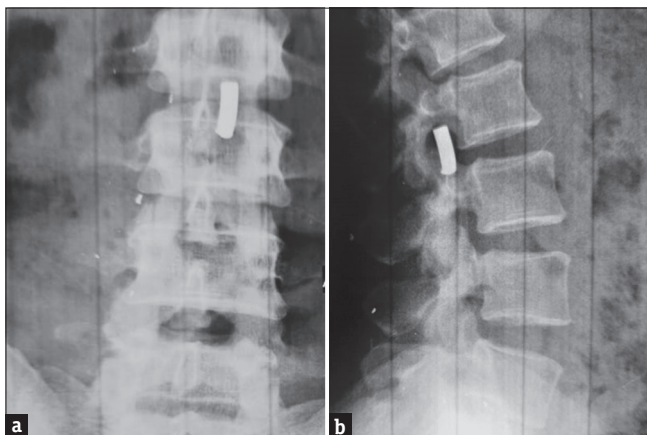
(a and b): Anterior posterior and lateral lumbosacral spine x-ray of patient on day of surgical procedure showing bullet at L2/3 with no evidence of bullet migration
